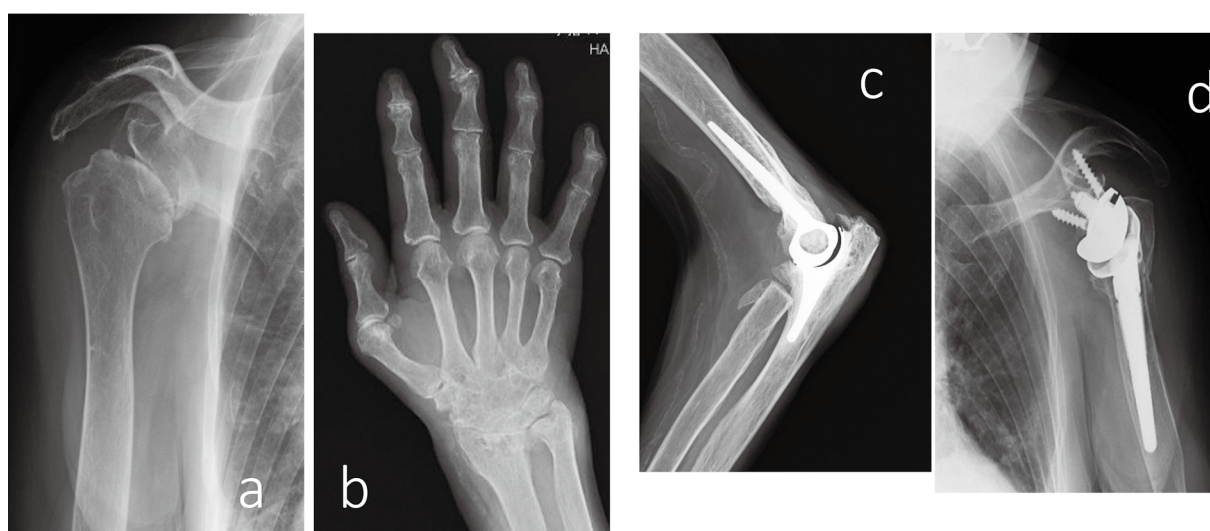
A preoperative plain X-ray of case 1. (a) Right shoulder joint Larsen classification Grade IV, (b) Right wrist Larsen classification Grade IV, (c) Left elbow joint after total elbow arthroplasty (TEA), (d) Left shoulder joint after reverse total shoulder arthroplasty (RSA).
